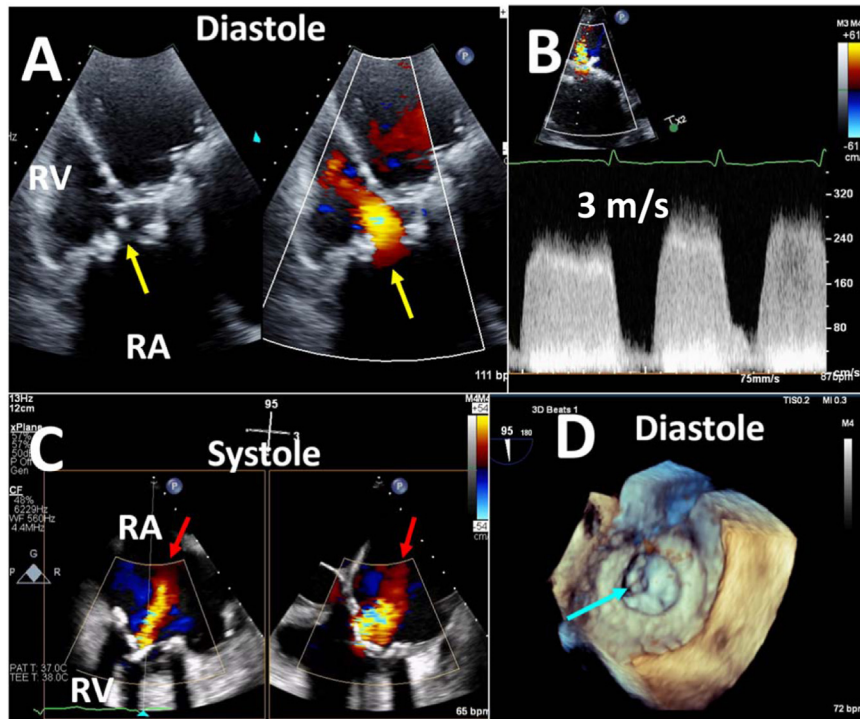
Transthoracic (A, B) and transesophageal (C, D) imaging of a patient with severe bioprosthetic TV stenosis. (A) Color-compare diastolic image showing the calcified and restricted leaflets (*yellow arrow*) with turbulent diastolic flow. CW Doppler (B) shows a peak velocity of 3.0 m/sec, with a mean gradient of 20 mm Hg. The transesophageal systolic image shows concomitant TR (*red arrows*) in the setting of markedly restricted bioprosthetic leaflet mobility. Three-dimensional imaging confirms severe restriction of all three leaflets with a small diastolic orifice (*blue arrow*). RA, Right atrium; RV, right ventricle.
